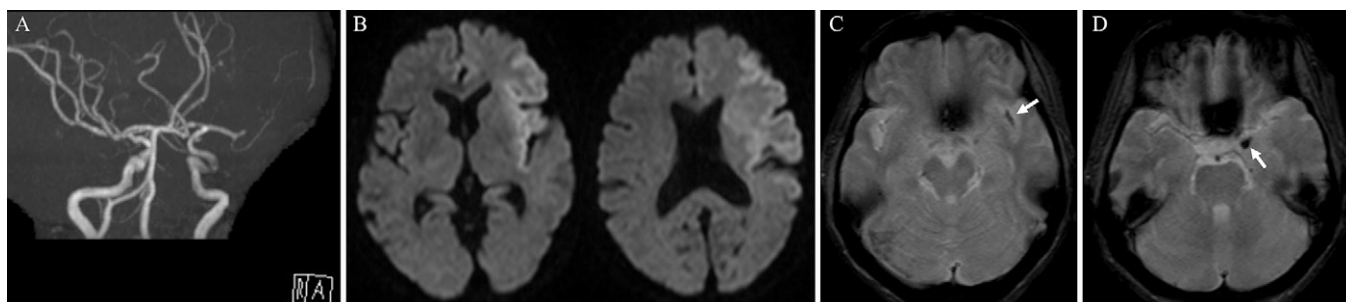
Imaging findings on admission. A: MRA demonstrated left M1 distal occlusion and small left ICA aneurysm. B: DWI demonstrated early ischemic lesions; the DWI-ASPECTS was 6. C: T2*WI showed the presence of a low intensity signal (*white arrow*), known as the susceptibility vessel sign, in the left MCA occlusion site. D: T2*WI showed a similar lesion at the left ICA aneurysm (*white arrow*).
